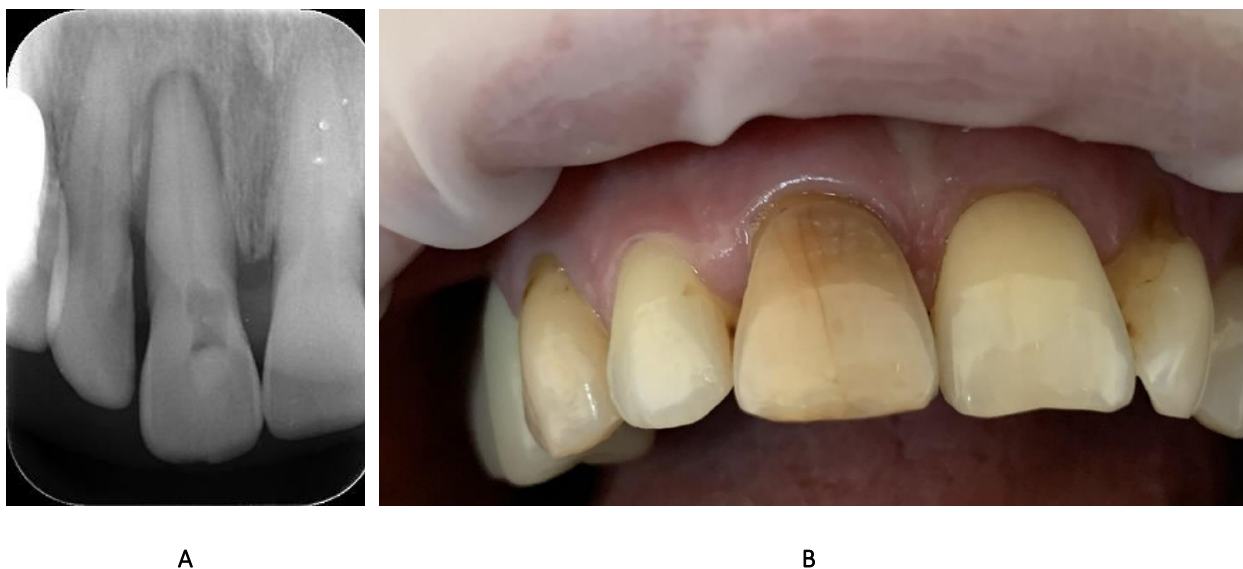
A-Radiography shows extensive periapical and lateral translucency; B-Discoloration of central incisor is clearly visible
